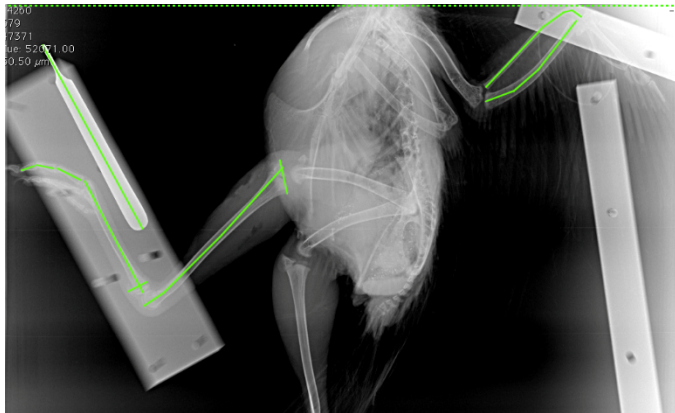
Example X-ray showing measurement lines for analysis.
